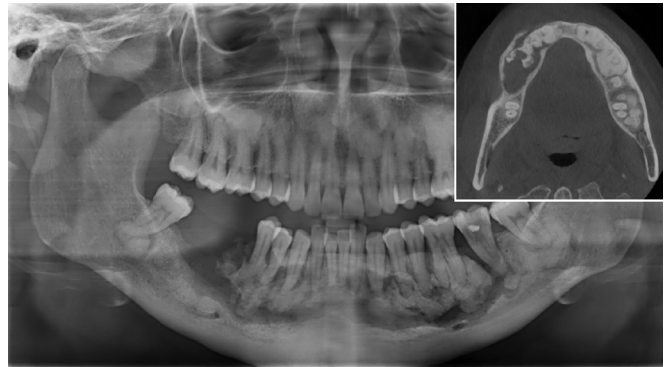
Florid cemento-osseous dysplasia with secondary osteomyelitis affecting most of the mandible following extraction of the right first mandibular molar 2 years ago. The expansion or widening of the radiolucent rim is seen as a sign of osteomyelitis. On CBCT imaging (insert), there is a slight bony expansion involving the left mandible, with a more pronounced expansion seen on the right side due to secondary infection.
